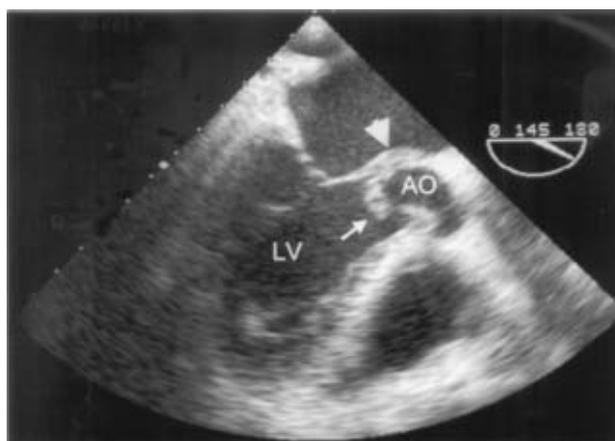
Transesophageal image in long-axis view of the aortic valve showing flailed aortic valves (arrow) with vegetation and infectious extension to the perivalvular tissue (arrow head). AO, aortic ring; LV, left ventricle.
